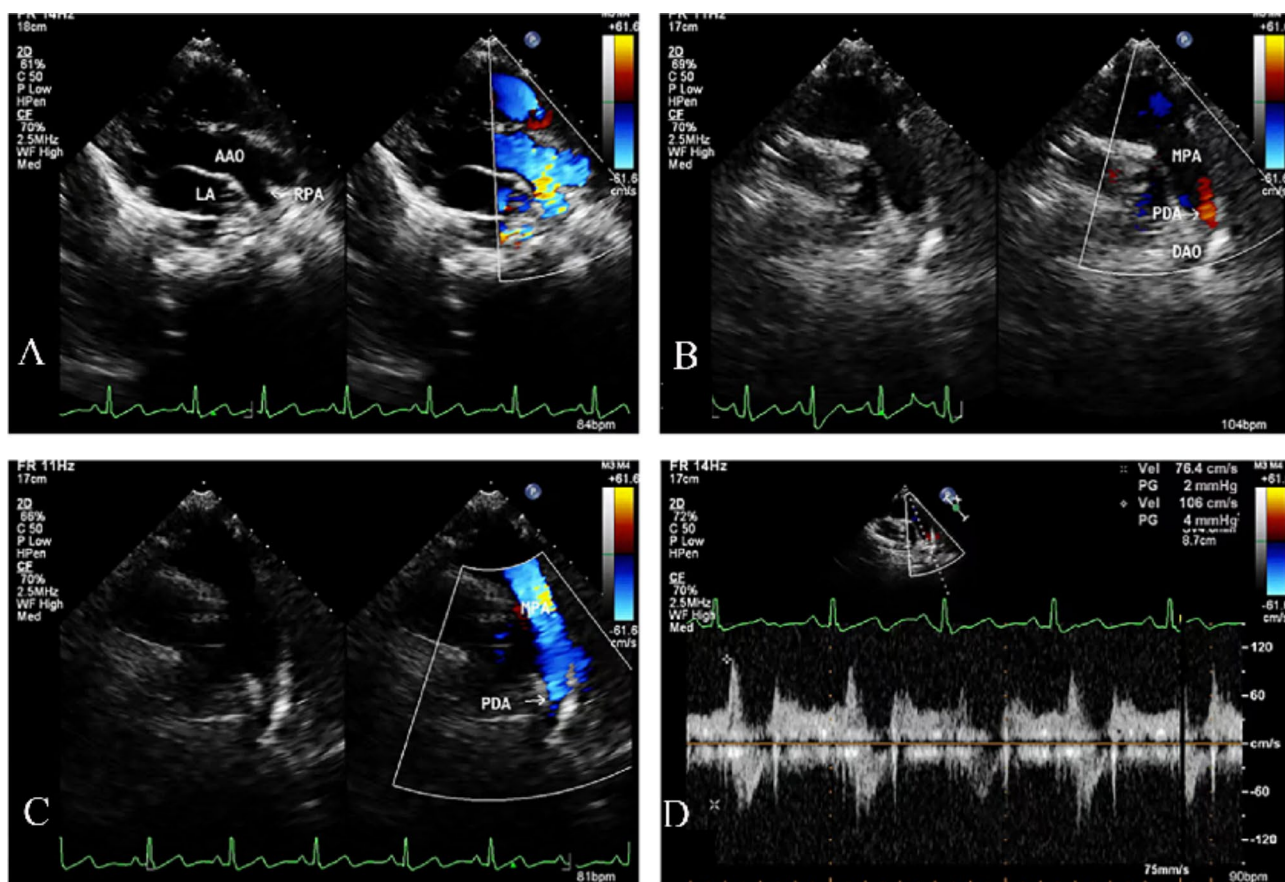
Preoperative transthoracic echocardiography. (A) Parasternal aortic long-axis view; (B-C) parasternal short-axis view; (D) pulmonary artery long-axis view. LA, left atrium; MPA, main pulmonary artery; RPA, right pulmonary artery; PDA, patent ductus arteriosus; AAO, ascending aorta; DAO, descending aorta
